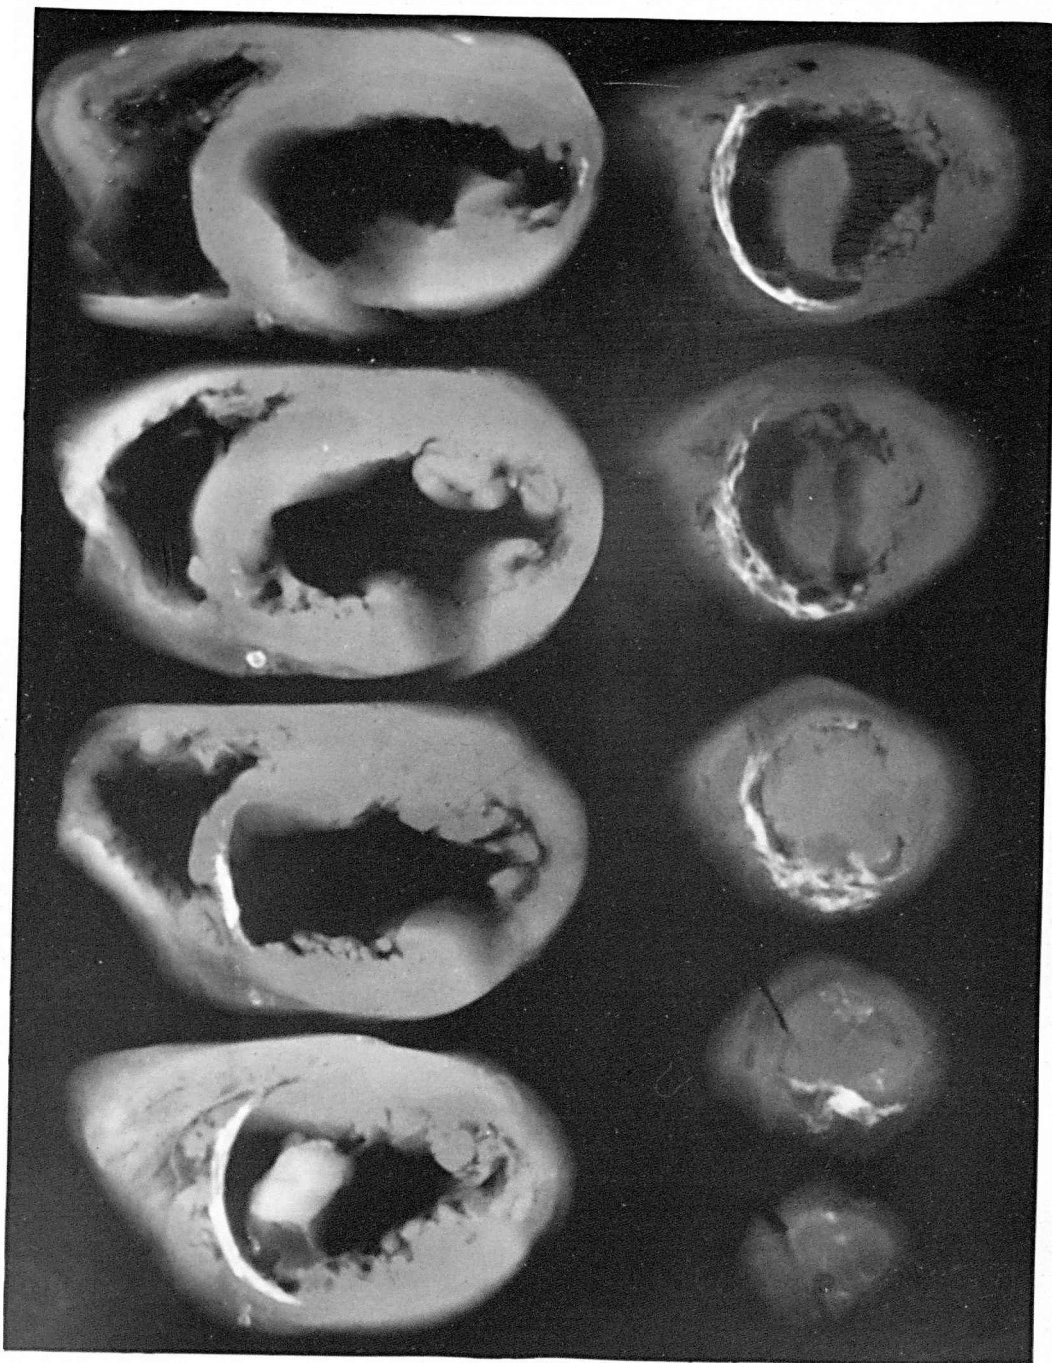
Radiograph of the serial slices to show
